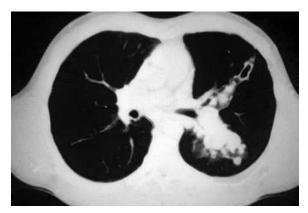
Allergic bronchopulmonary aspergillosis. Chest CT of a patient with asthma and allergic bronchopulmonary aspergillosis shows consolidation, atelectasis, and dilated bronchi radiating from the hilum.
